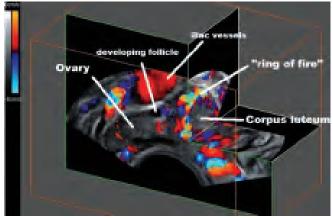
A 3D color Doppler image demonstrating open cut view to the angiogenesis of the corpus luteum
